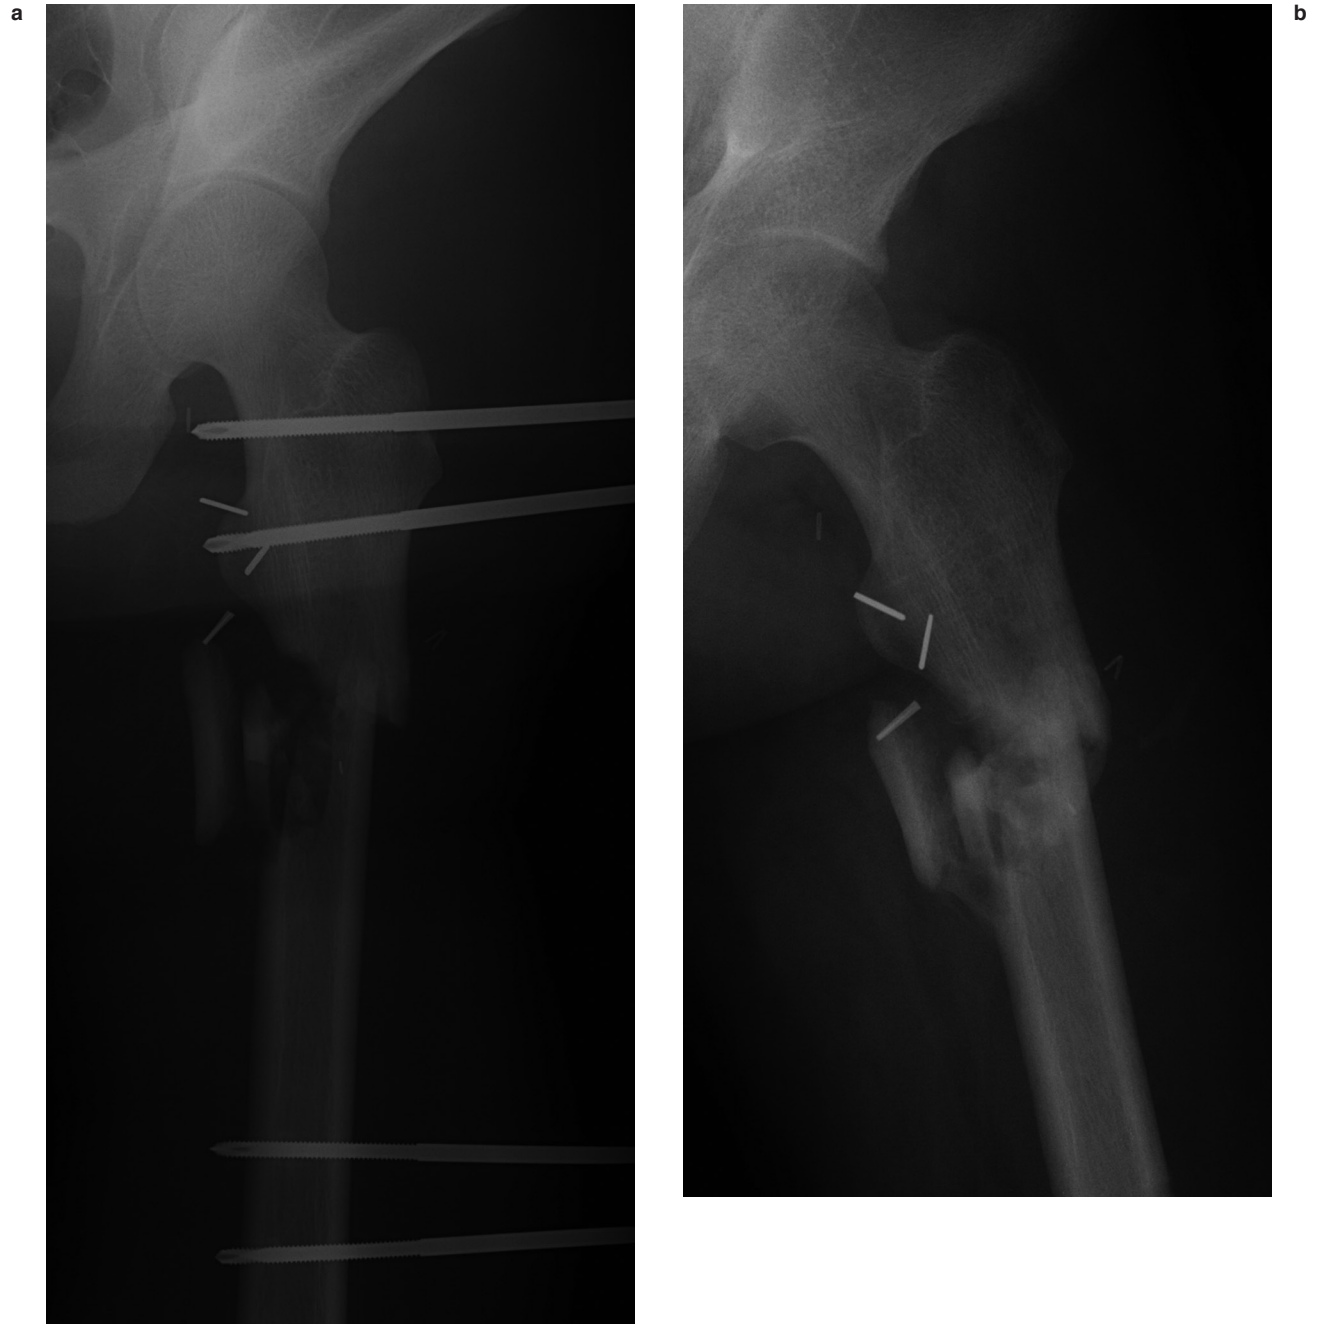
Radiographs of a through-knee amputation with external fixation of a proximal femur fracture. Due to soft tissue compromise and other injuries limiting potential early rehabilitation, the patient was treated definitively in this fashion until sufficient callous had formed to allow ambulation, with some additional support provided externally by the prosthetic socket.
